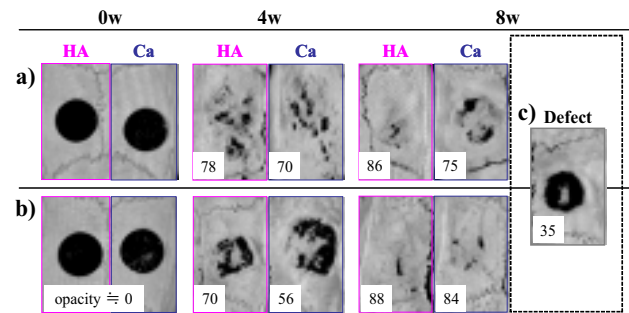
μ -CT images of the skull of a) Disk type, b) Homogenized type of HA and Ca gels after 0, 4, 8 weeks and c) Defect after 8 weeks.
